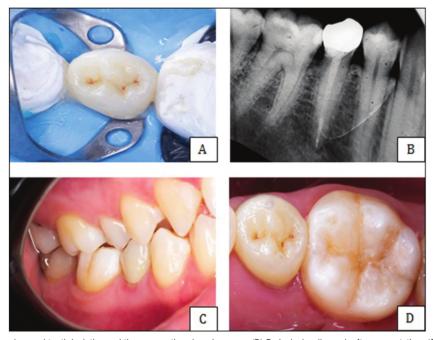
(A) Rubber dam and tooth isolation and then cementing zirconia crown. (B) Periapical radiograph after cementation. (C) Occlusion check. (D) After 2 weeks control
